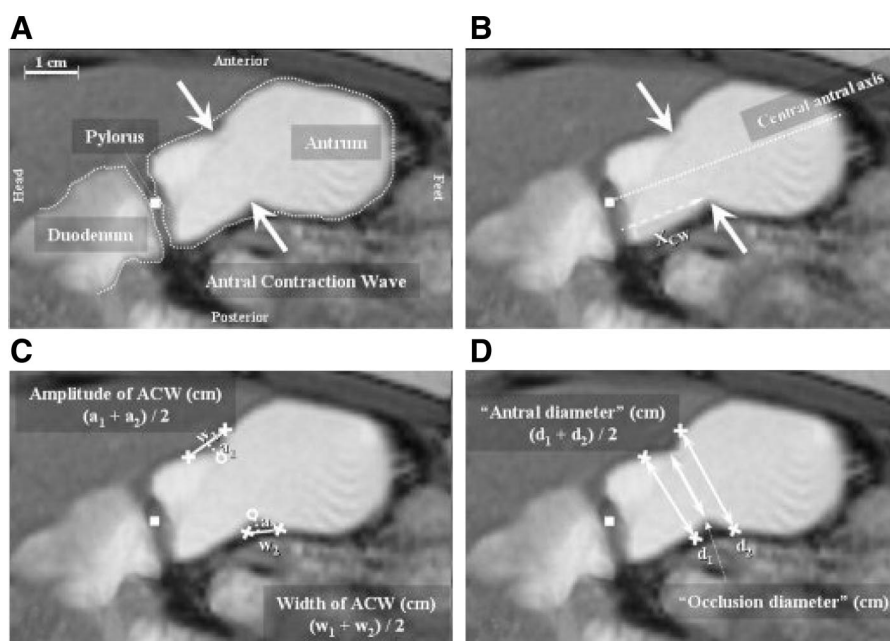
Computed analysis of antral contraction waves (ACWs) as seen by MRI. Presented here is a magnification of an image through the distal antrum, pylorus, and proximal duodenum. *A*: arrows indicate the position of ACWs propagating toward the pylorus, as captured in one of 120 images of a dynamic sequence (motility scan, 167 s). *B*: long axis drawn through the center of the antrum was anchored to the indicated position of the pylorus, allowing tracking of the propagation of ACWs, as well as their position relative to the pylorus (X_{CW} , in cm). *C*: average distance (w_1 and w_2 , in cm) between the bases (\times) of the indentations in the antral wall, representative of ACWs, denoted the width of ACWs. The average distance (a_1 and a_2 , in cm) between the tips (\circ) of these indentations and the w_1/w_2 denoted the amplitude of ACWs. *D*: antral diameter was measured as an average of 2 distances (d_1 and d_2 , in cm) between the bases (\times) of ACWs across the antrum. Similarly, the occlusion diameter was measured as a distance between the tips (\circ) of ACWs. Reproduced from Kwiatek MA, Steingoetter A, Pal A, Menne D, Brasseur JG, Hebbard GS, Boesiger P, Thumshirn M, Fried M, Schwizer W. Quantification of distal antral contractile motility in healthy human stomach with magnetic resonance imaging. *J Magn Reson Imaging* 24: 1101–1109, 2006. Reprinted with permission of John Wiley & Sons, Inc.
